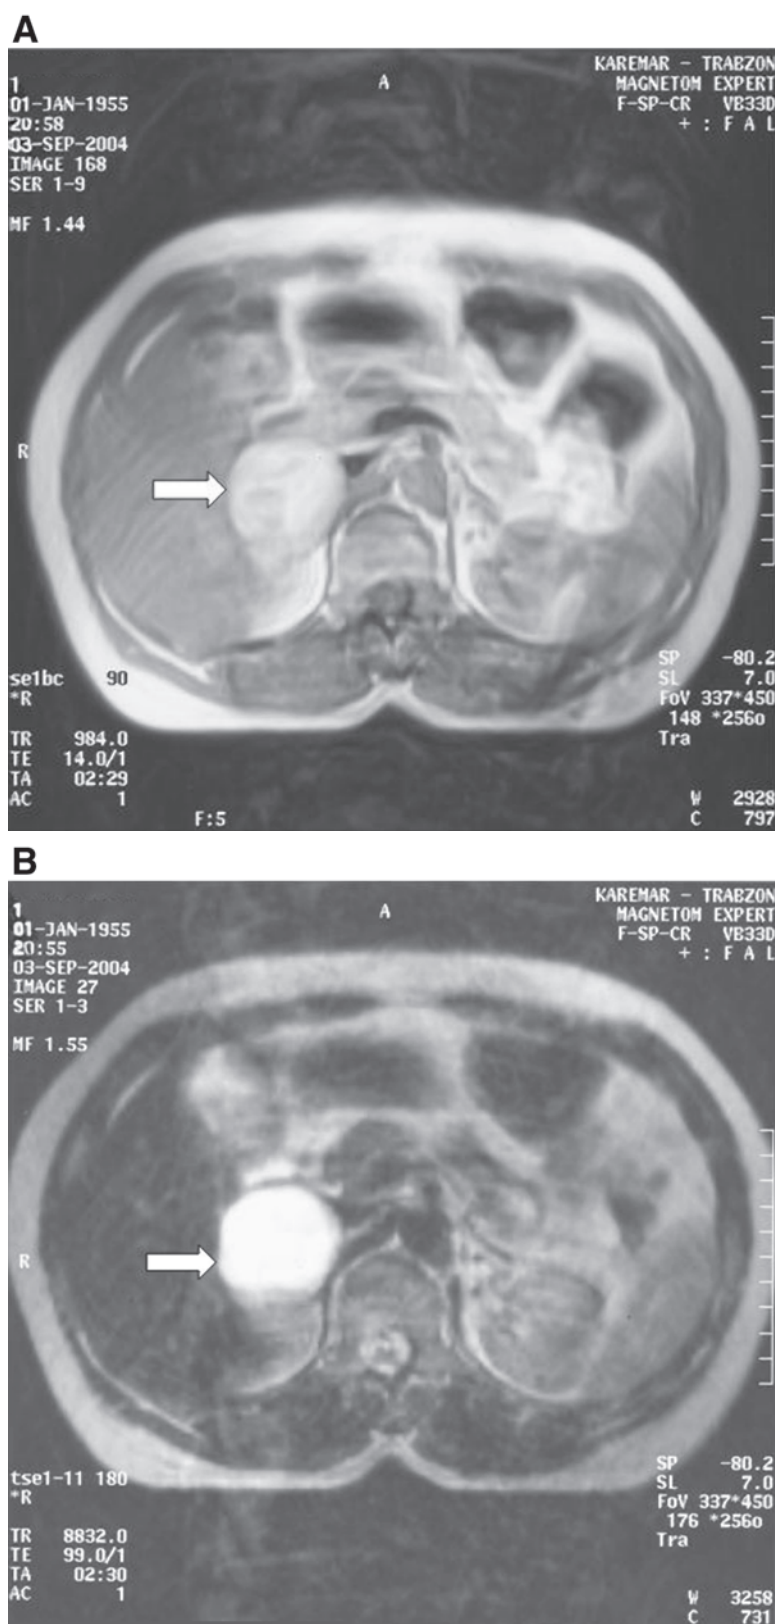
(A) T₁-weighted and (B) T₂-weighted magnetic resonance images reveal high signal intensity of the cystic PHEO at the right adrenal gland (arrows). Hyperintensity in tumor is more prominent at T₂-weighted MR image.
